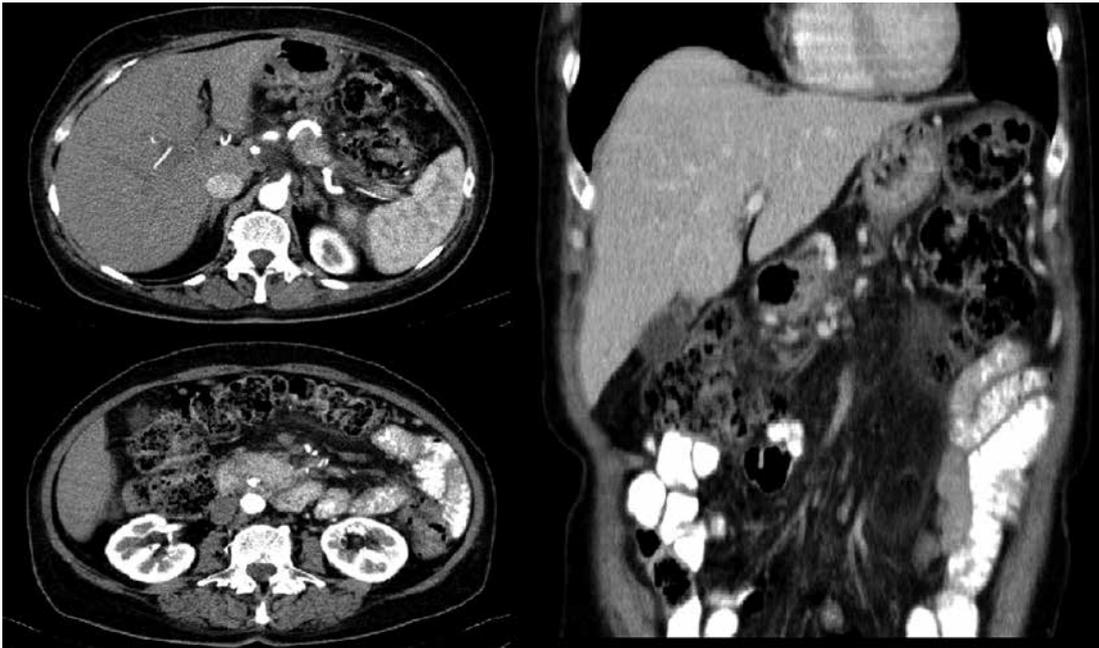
Contrast-enhanced computed tomography of the abdomen performed after endoscopic treatment
